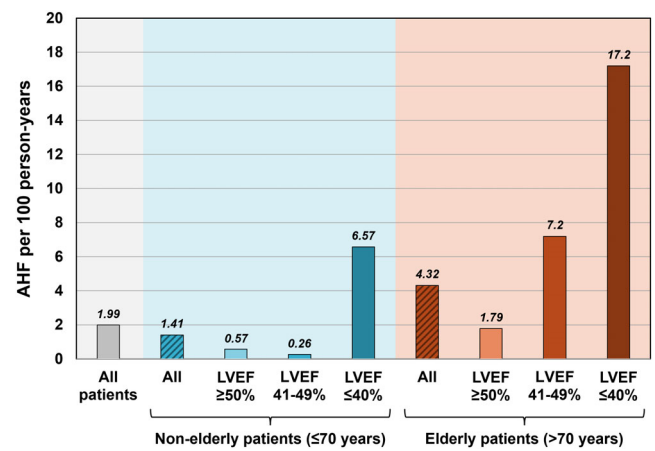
Rate of AHF per 100 person-years across 1-week MRI-LVEF categories. Results are shown for nonelderly and elderly patients. AHF = acute heart failure; LVEF = left ventricular ejection fraction.
